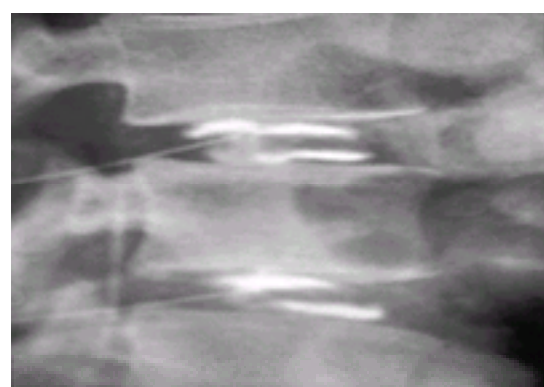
Radiograph of a discogram.
